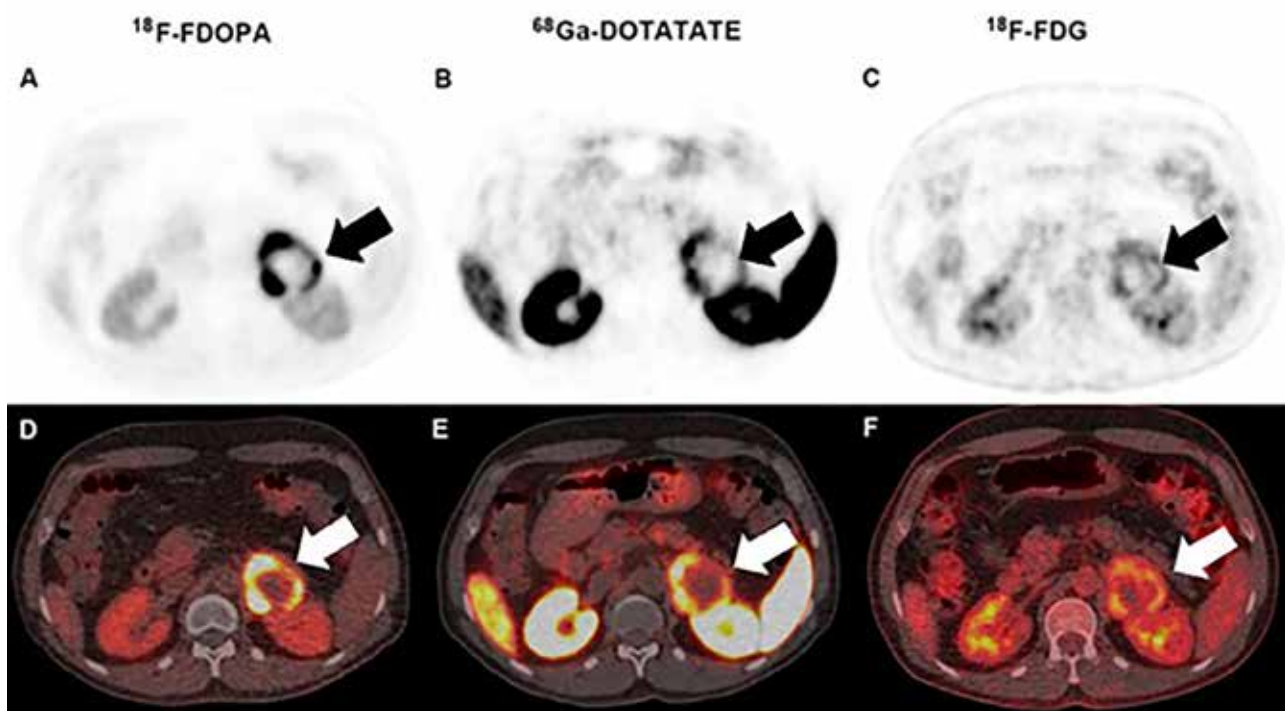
An avid peripheral uptake of radioisotopes with central photopenia (arrow) is depicted in the left adrenal gland on axial attenuation-corrected ^{18}F -FDOPA, ^{68}Ga -DOTATATE, ^{18}F -FDG PET (A-C) and PET/CT (D-F) images. These features imply the presence of pheochromocytoma. (Taieb D, Jha A, Guerin C, Pang Y, Adams KT, Chen CC, Romanet P, Roche P, Essamet W, Ling A et al. ^{18}F -FDOPA PET/CT imaging of MAX-related pheochromocytoma. *J Clin Endocrinol Metab* 2018; 103(4): 1574-1582)
